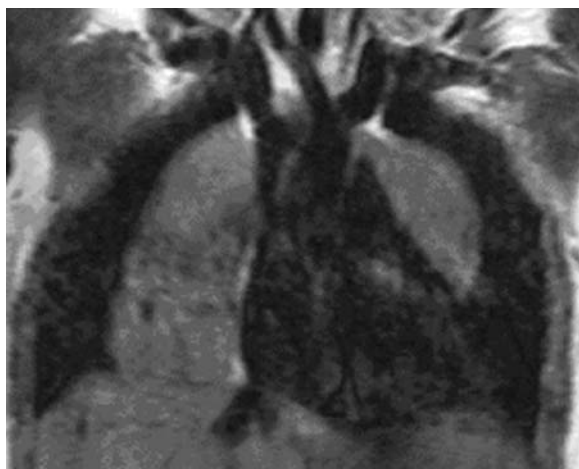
Coronal section. Examination in SE, T1-weighted sequence. A tumor around the right and left border of the heart.
